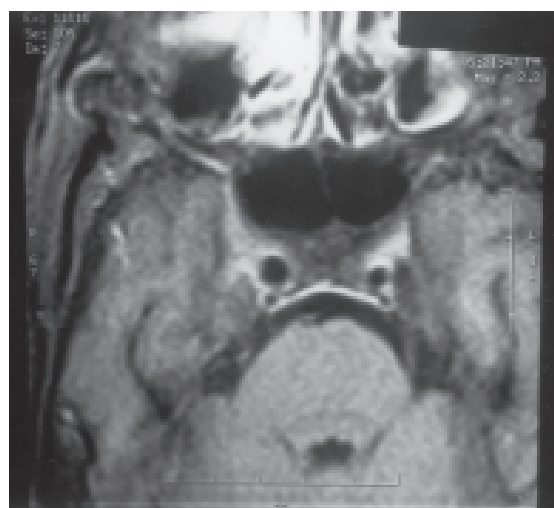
MRI brain T<sub>1</sub> W with contrast study showing a well-defined uniformly enhancing lesion in the right paracavernous region extending to the right orbital apex. Intense enhancement is seen in the right ethmoidal sinuses.
